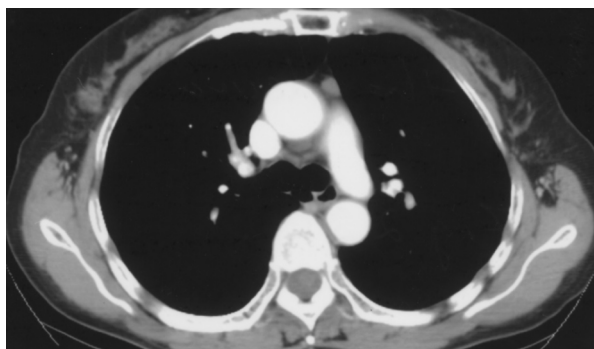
CT scan of the chest revealing a small homogenous soft tissue nodule in the anterior mediastinum abutting the ascending aorta.
